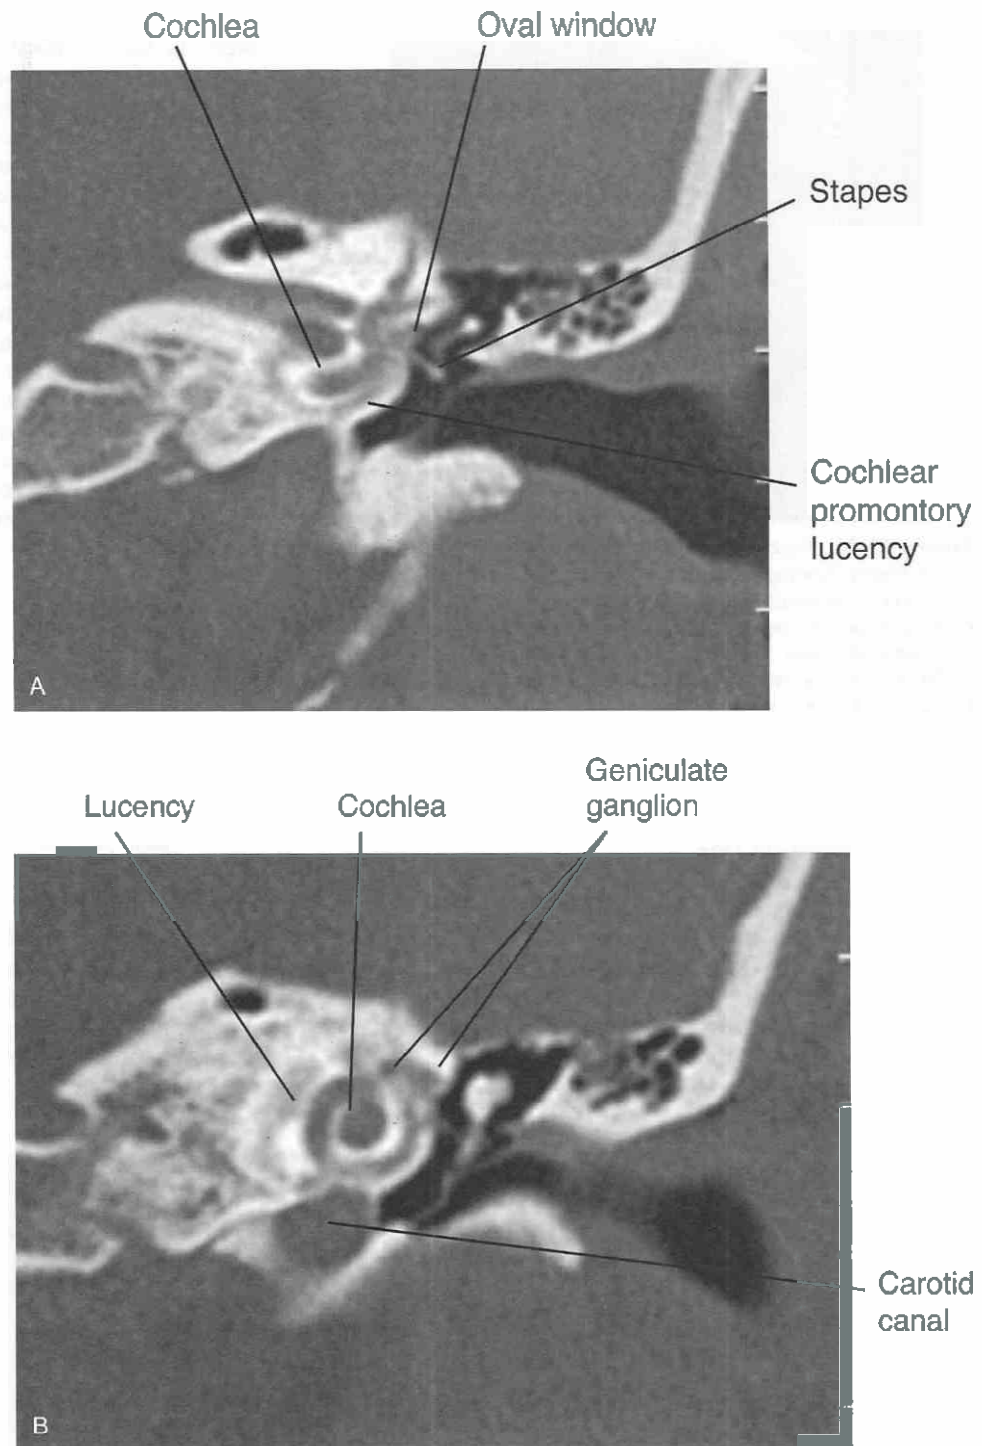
Osteogenesis imperfecta in a young patient with hearing loss and facial palsy. *A*, Coronal CT image demonstrates a broad lucency adjacent to the basal turn of the cochlea. There is also thickening of the soft tissues filling the oval window niche, mimicking severe fenestral and cochlear otosclerosis. *B*, Coronal image, anterior in relationship to *A*, shows erosive changes involving the geniculate ganglion region and paralleling the cochlea.
